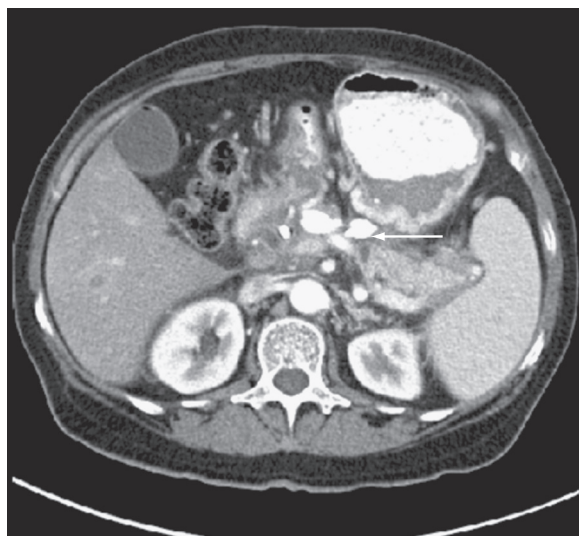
■ Interval computed tomography in the same patient as in Fig. 99-6, with pancreatic necrosis and pseudocyst formation. Significant resolution was observed after internal endoscopic drainage, with two stents functioning as a cystogastrostomy (arrow).
